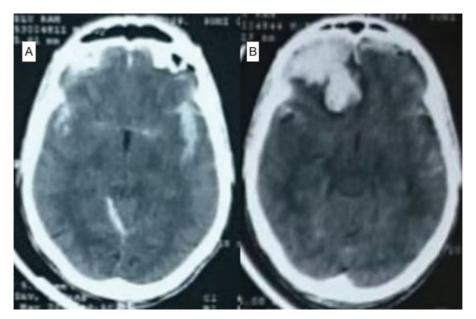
Computed tomographic (CT) scans showing example of progression of contusion associated with subarachnoid hemorrhage in a 45-year-old man after road traffic accident. Patient required surgical intervention. (A) Initial CT scan. (B) CT scan after 24 hours.
